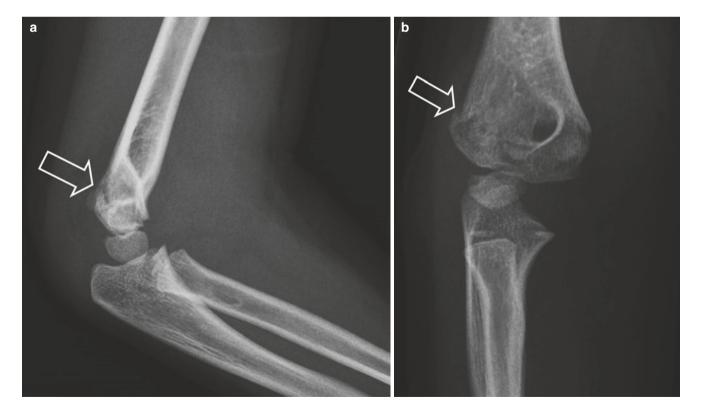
(a) AP and (b) lateral radiographs of the elbow of a 6-year-old child who fell out of a bunk bed
